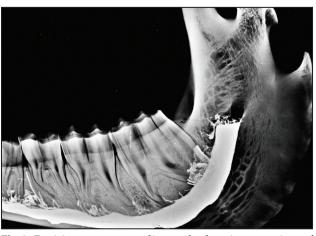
Positive contrast radiograph showing opening of mandibular foramen at vertical ramus of mandible.
